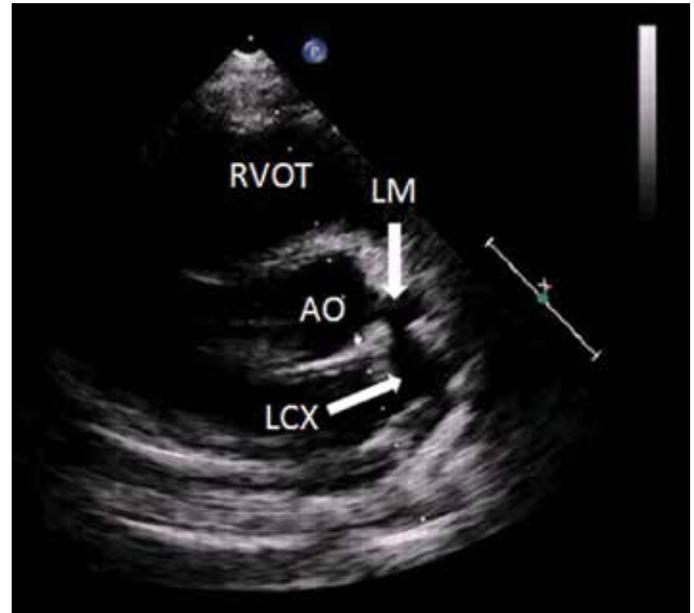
In the parasternal short-axis view at great arteries level transthoracic two-dimensional echocardiography shows the left main coronary artery (LM) and left circumflex artery (LCX) dilated
